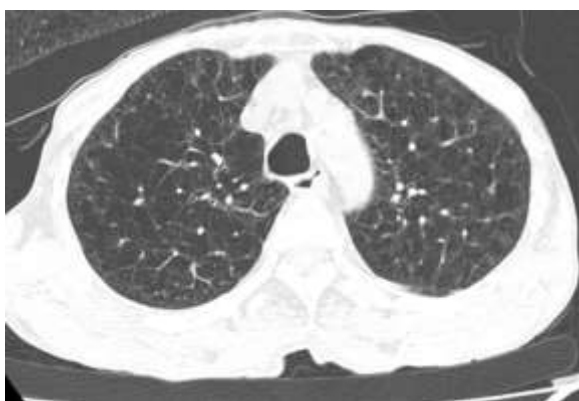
Presence of inhomogeneous attenuation as shown in chest high-resolution computed tomography
